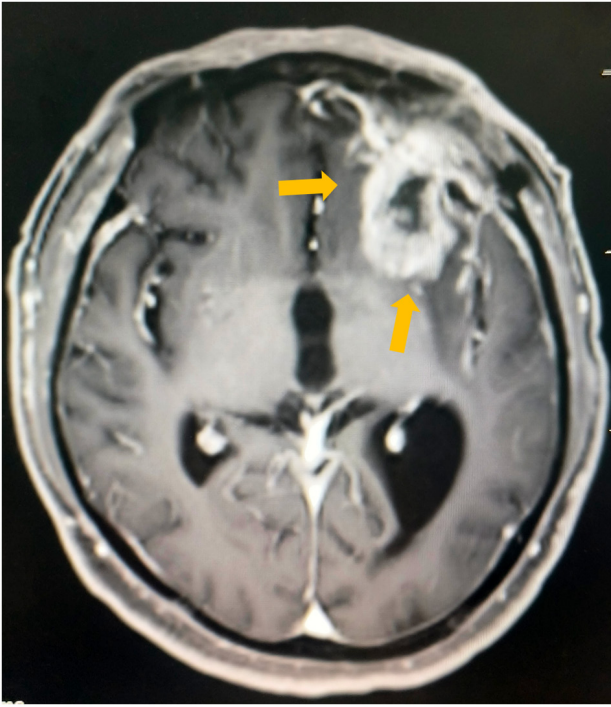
The postoperative review in September 2024 revealed an abnormal signal in the surgical area of the left frontal lobe, suggesting potential tumor recurrence. (yellow arrow) (MRI).
